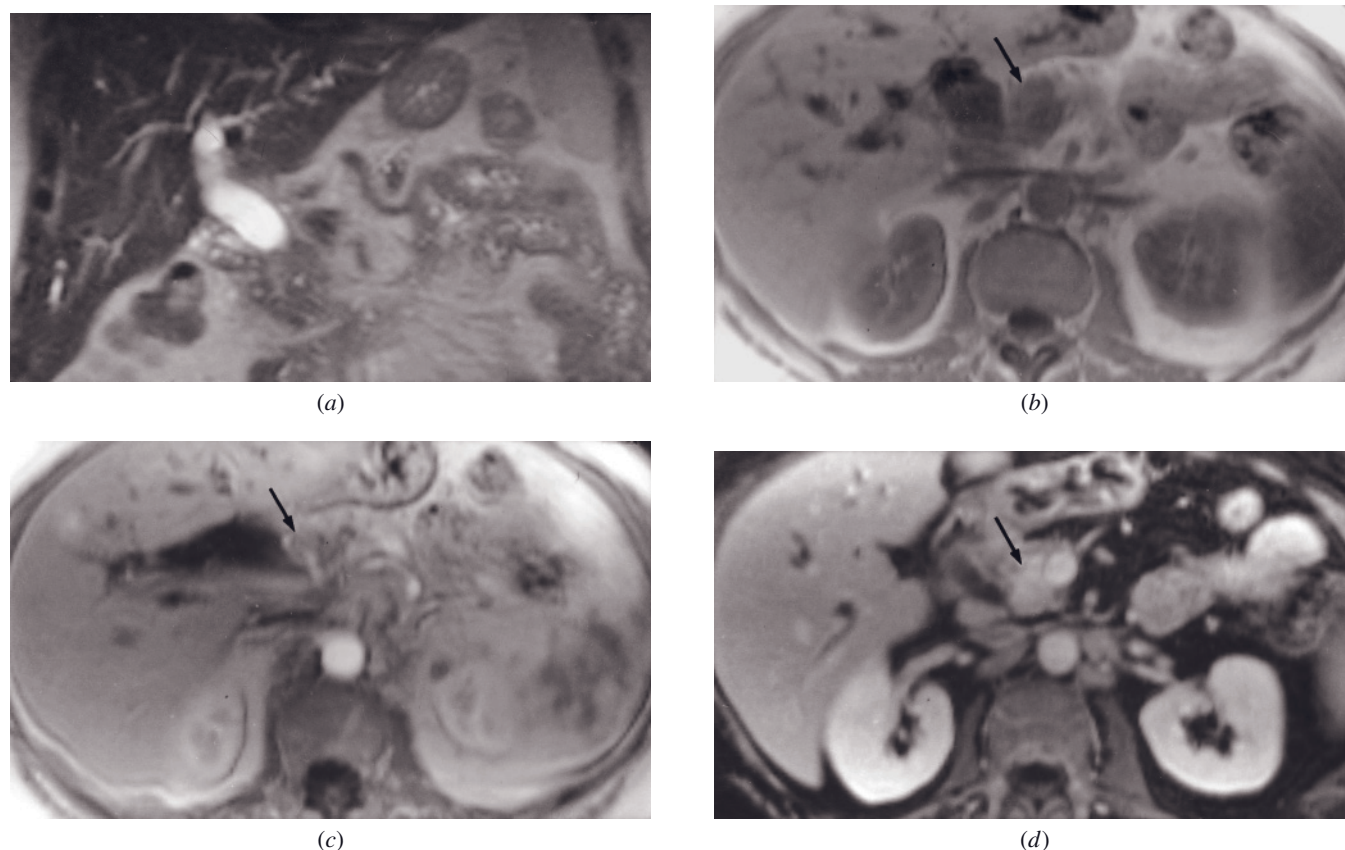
Infiltrative pancreatic cancer arising in the upper head and neck. Coronal T2-weighted SS-ETSE (a), T1-weighted SGE (b), immediate postgadolinium T1-weighted SGE (c), and 90-s postgadolinium fat-suppressed SGE (d) images. A 3-cm poorly differentiated infiltrative adenocarcinoma is present in the pancreatic head, which causes high-grade obstruction of the CBD. The tumor is ill defined on all imaging sequences (arrow, b, c) and demonstrates late increased enhancement (arrow, d). These are features of an infiltrative desmoplastic neoplasm.
